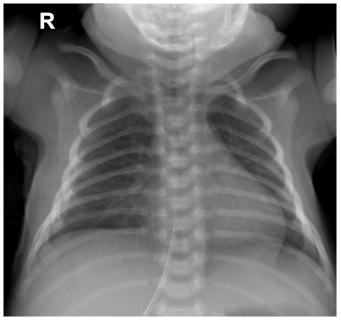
Radiography - Day 6: Complete re-expansion of both lungs.
